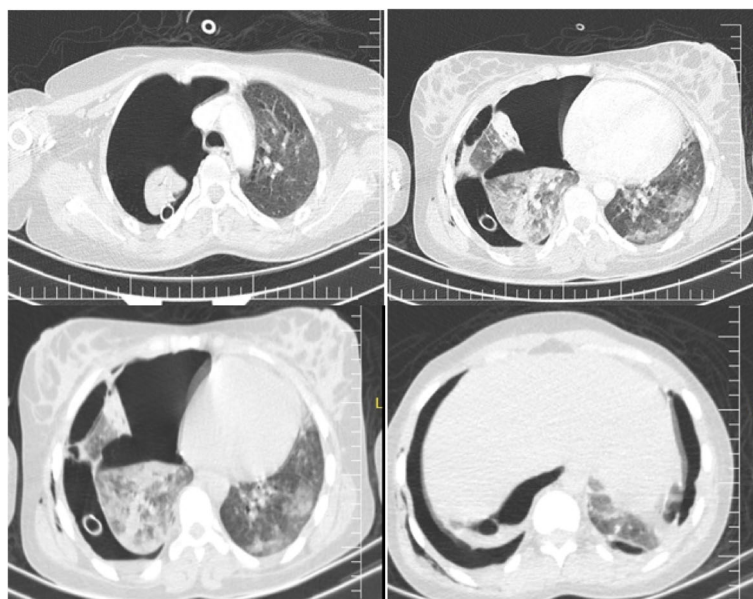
Computer tomography (CT) scan of the chest shows tension pneumothorax on the right and a minimum pneumothorax on the left, as well as diffuse ground-glass opacities and consolidation throughout both lung fields
